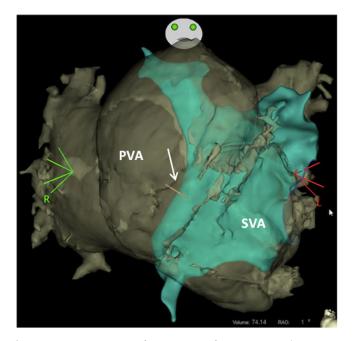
Dextro-transposition of great arteries, after senning procedure. CT scan images were merged with real-time 3D electroanatomical mapping (CARTO 3, biosense webster, inc) allowing the reconstruction of the the systemic (SVA) and pulmonary venous atria (PVA) and the visualisation of the needle tip during transbaffle puncture. Posterior view, the senning baffle is highlighted in blue. The white arrow indicates the transbaffle puncture. PVA = pulmonary venous atrium, SVA = systemic venous atrium.
